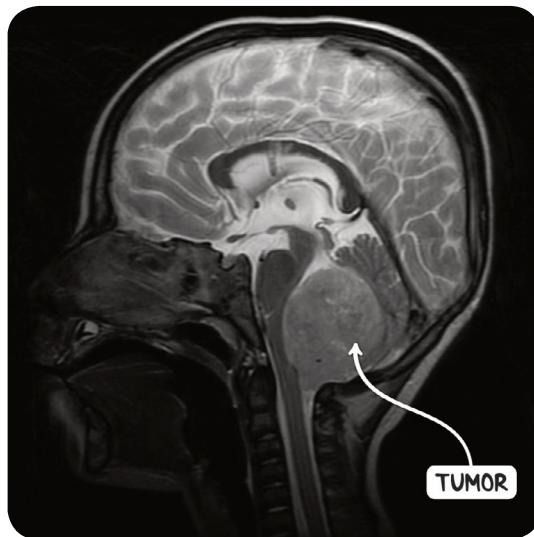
An MRI scan of the head of a child demonstrating an ependymoma in the posterior fossa, compressing the cerebellum.
